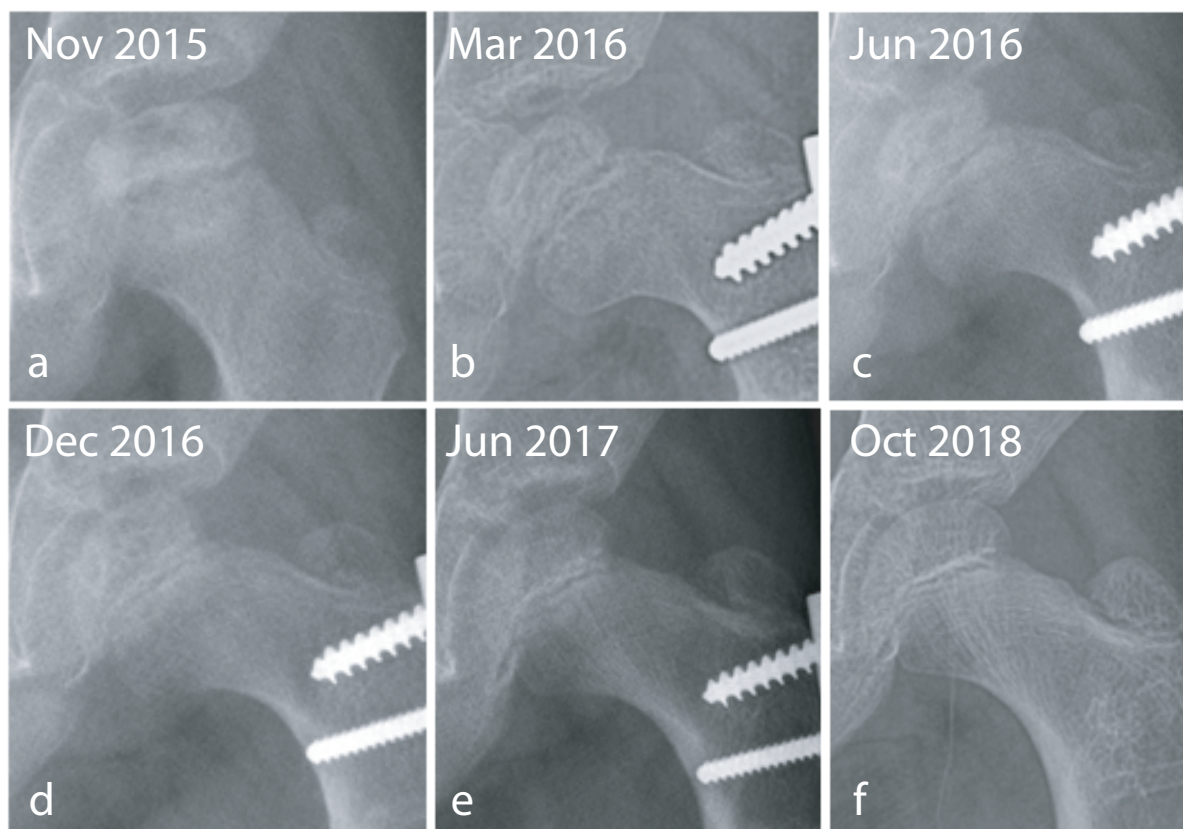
Sequential radiographs of the hip of a boy with Perthes disease who underwent a proximal femoral varus derotation osteotomy within a month after presentation in stage Ib of the disease (a). In none of the sequential radiographs are there fissures in the epiphysis typical of fragmentation (b-d). The continuity of the articular margin of the femoral epiphysis has been maintained throughout the course of the disease. The disease healed within 17 months of surgery (e) and the outcome was excellent (f). The stage of fragmentation has been bypassed.
